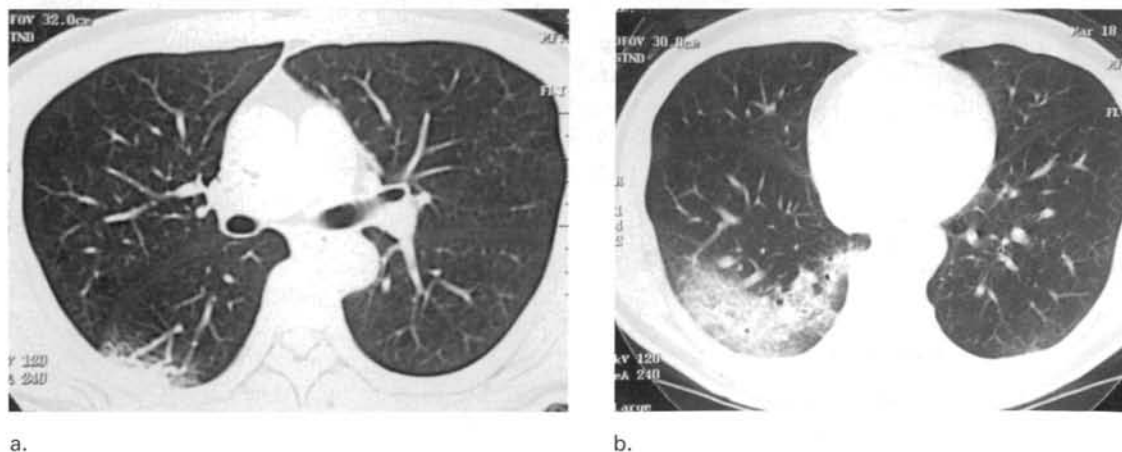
CT scans showing progression of disease in a 56 year-old patient with SARS. (a) CT scan at presentation when the chest radiograph was normal. There was a small subpleural area of ground glass opacity and consolidation in the apical segment of the right lower lobe. (b) After 6 days, this had progressed to involve most of the sub pleural regions of the right lower lobe. Note the consolidation with adjacent ground glass opacification.
